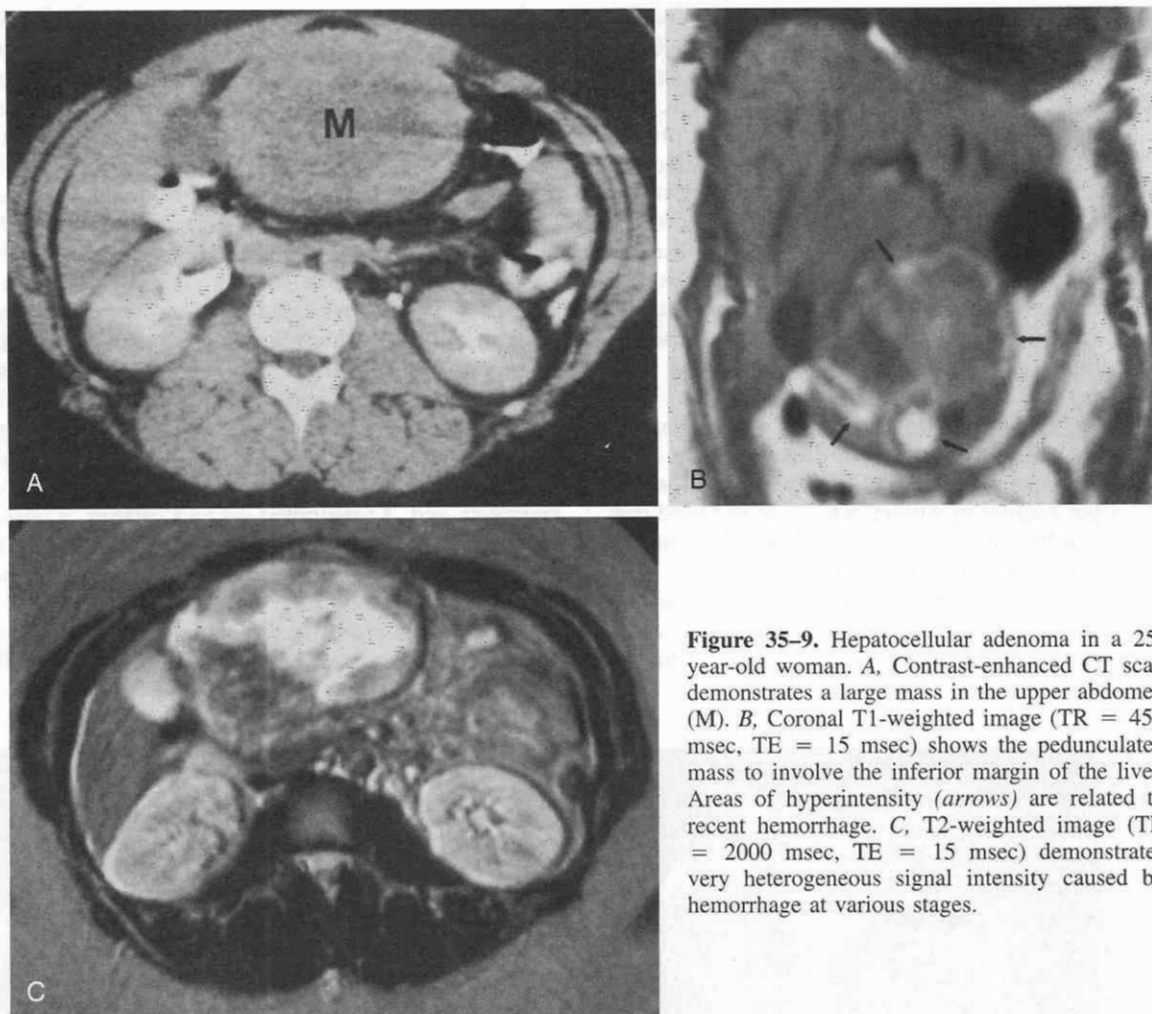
Hepatocellular adenoma in a 25-year-old woman. A, Contrast-enhanced CT scan demonstrates a large mass in the upper abdomen (M). B, Coronal T1-weighted image (TR = 450 msec, TE = 15 msec) shows the pedunculated mass to involve the inferior margin of the liver. Areas of hyperintensity (arrows) are related to recent hemorrhage. C, T2-weighted image (TR = 2000 msec, TE = 15 msec) demonstrates very heterogeneous signal intensity caused by hemorrhage at various stages.
